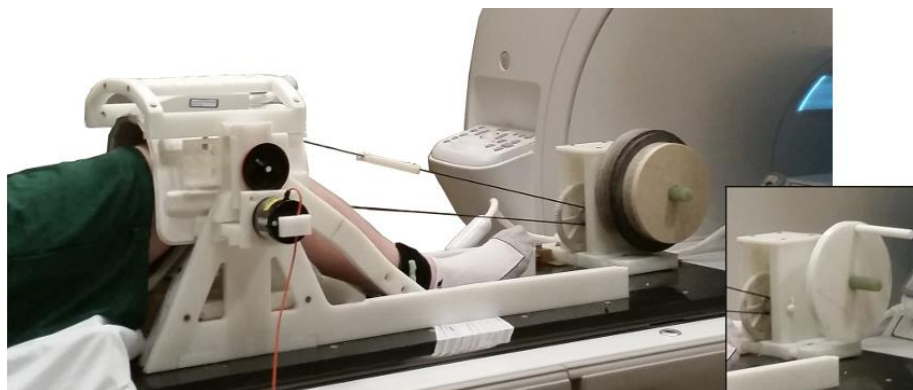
MRI-compatible loading device with inertial disks used for active loading scenario and (insert) handle to facilitate passive loading scenario.
